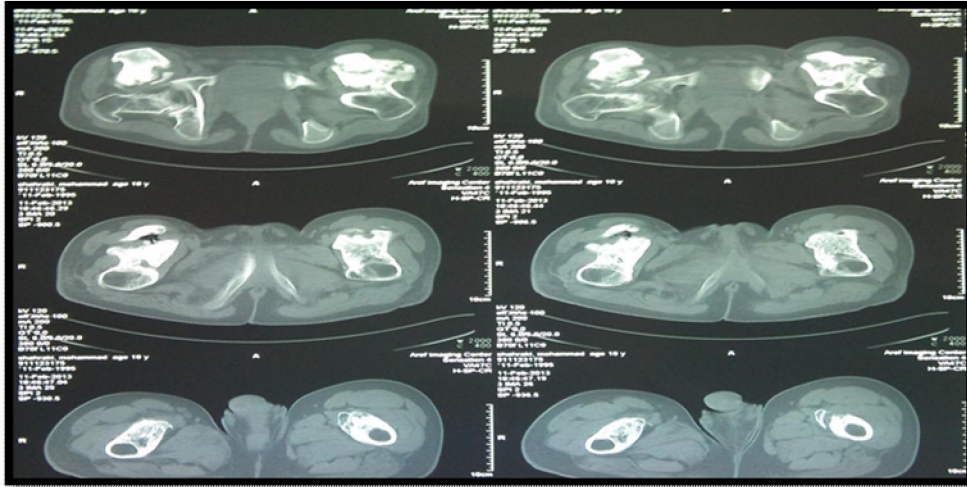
Axial CT scan demonstrates a heterotopic mass appearing to involve the hip
